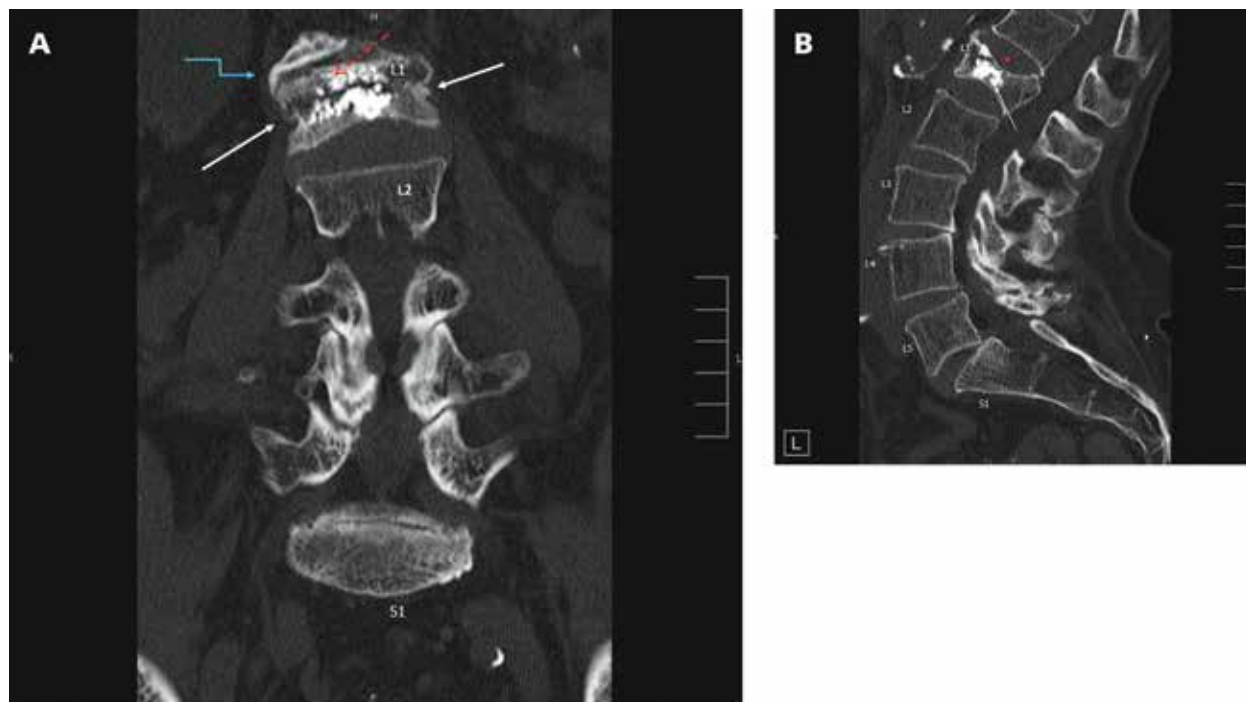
A. Coronal CT of the thoracolumbar spine in bone windows demonstrating a horizontally oriented fracture cleft (white arrows) through the L1 vertebral body with vertical extension through the right lateral aspect of the superior endplate (dashed red arrow). The fracture involves both the osseous and previously cemented PMMA components of the vertebral body. Note the bridging T12/L1 paraspinal osteophyte and associated disc degenerative changes (blue arrow). B. Sagittal CT of the thoracolumbar spine in bone windows demonstrates an endplate compression fracture of the L1 vertebral body with changes related to prior augmentation (white arrow). There is an acute fracture cleft through the osseous and PMMA cement of the anterior and middle third of the vertebral body (red arrow) with extension through the superior endplate. Of note, severe generalized osseous demineralization is present.
